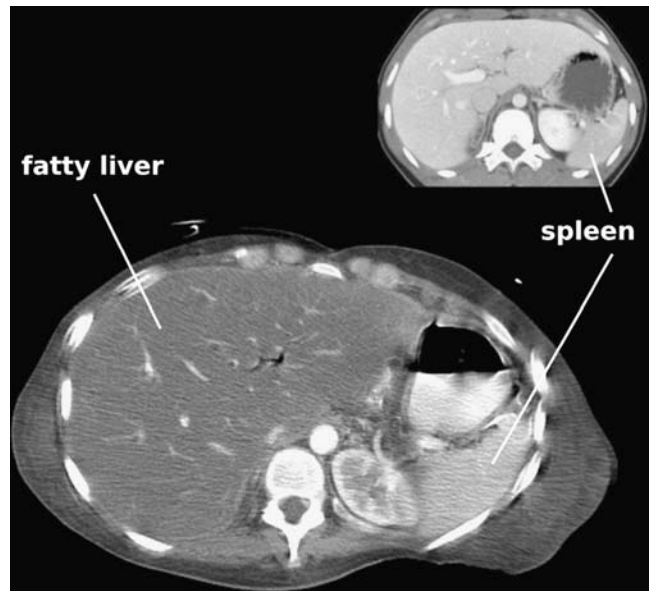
Contrast-enhanced abdominal CT. Shown is a cross-sectional image from the patient's abdominal CT. The decreased attenuation of the liver in comparison with the spleen is characteristic of diffuse fatty infiltration. The inset displays an example of normal hepatic attenuation
